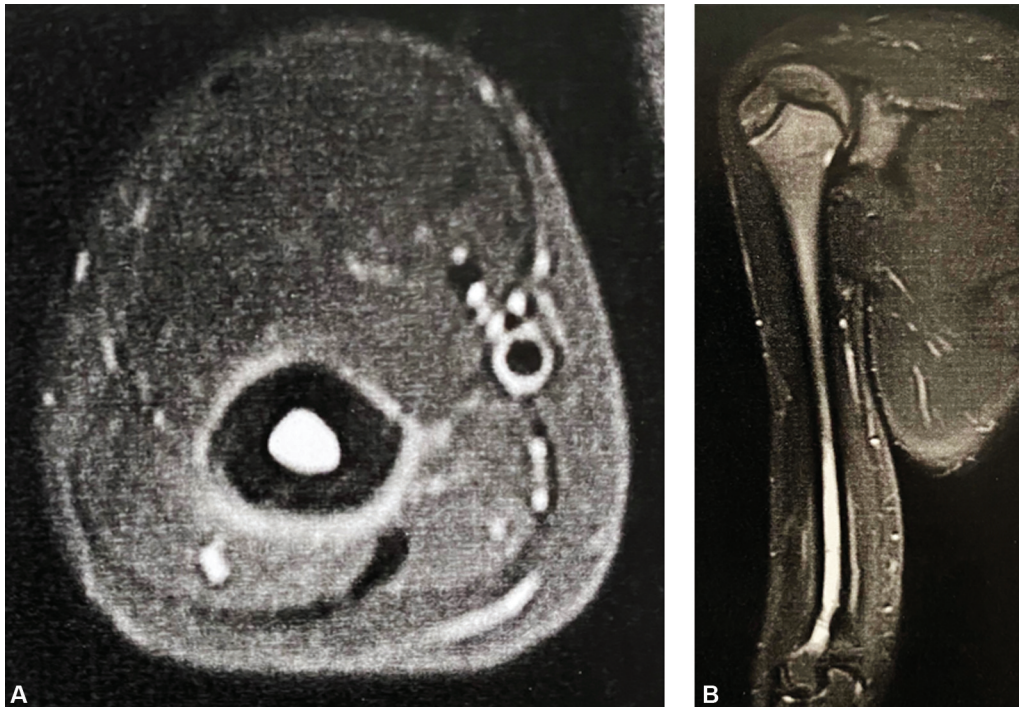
Axial (A) and coronal (B) fat-suppressed T2-weighted magnetic resonance imaging showing significant bone marrow and periosteal edema in the lower half of the humerus diaphysis.
